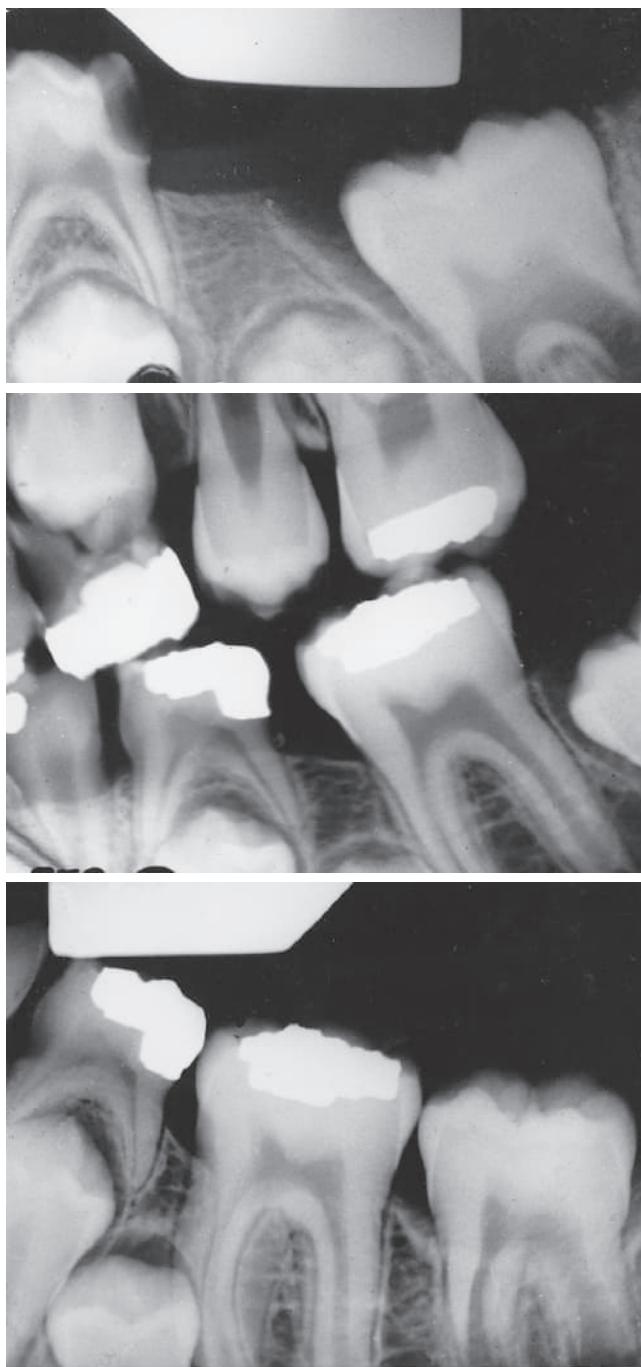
A sequence of three radiographs showing early loss of a lower second primary molar and mesial movement of the first permanent molar before eruption. Eventually there was complete closure of the space needed for the second premolar.
